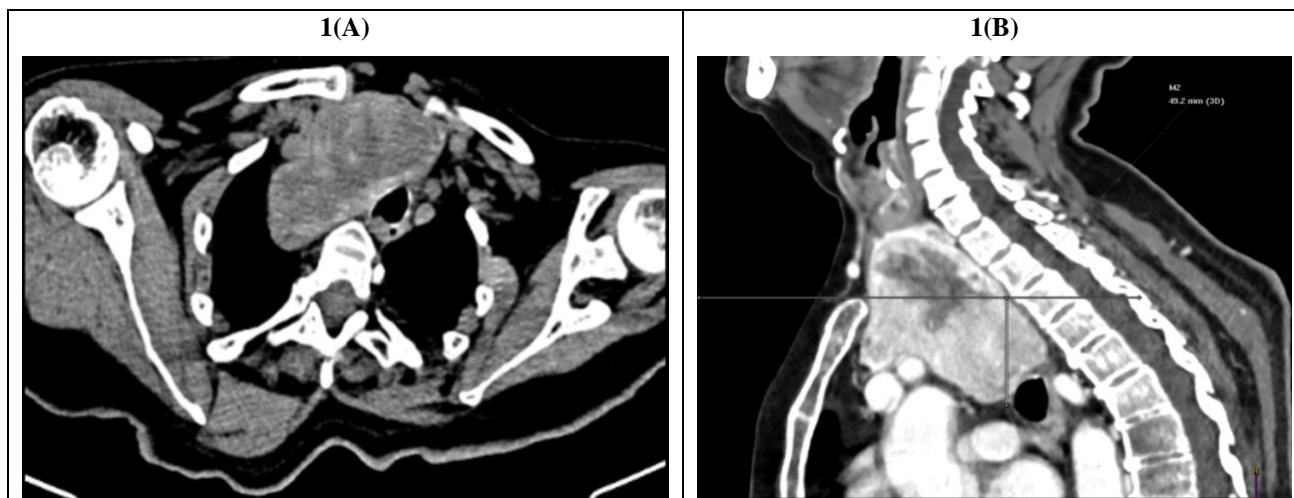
Computed tomography images show (A): multinodular goiter, with predominantly right lobe enlargement with tracheal compression; (B): multinodular goiter occupying mediastinum.
